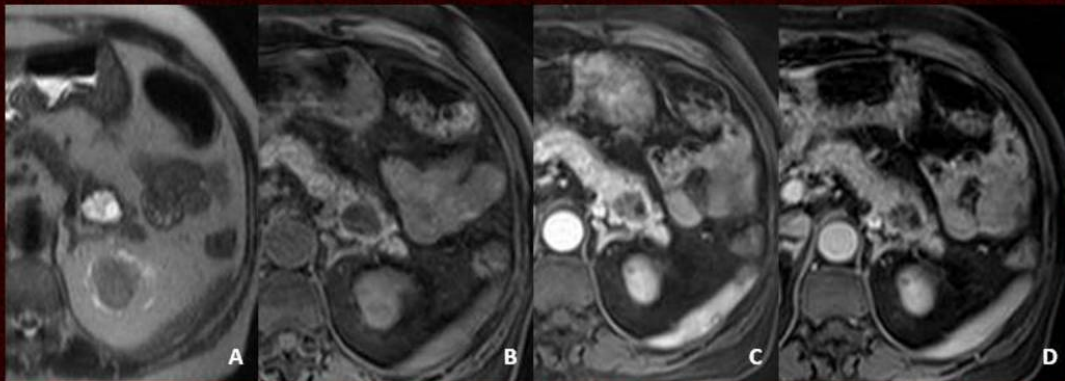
Abdominal MR images in a 73-year-old female patient demonstrate a complex cystic lesion in the pancreatic tail. On T2-weighted images (A) the lesion shows heterogeneous internal structure. The dynamic study (B-D) reveals enhancing solid components. The findings are consistent with a mucinous cystadenocarcinoma.
